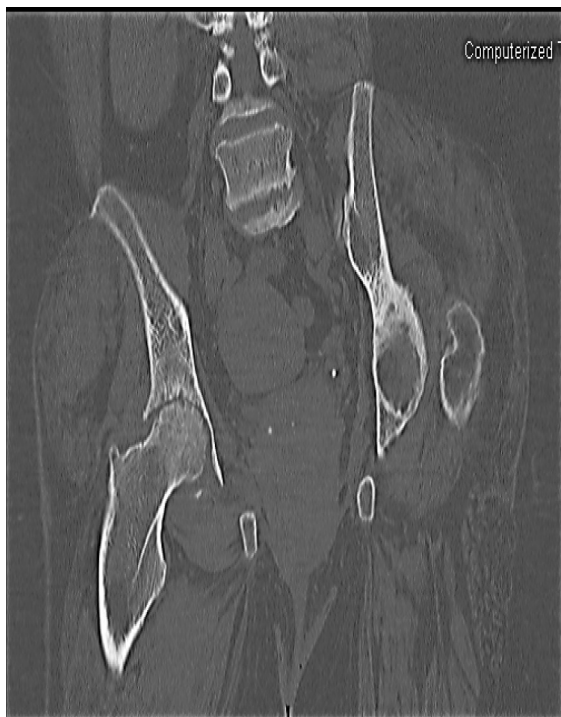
B Coronal CT scan of the pelvis without contrast: advanced degenerative changes in both hip joints with partial resorption of right femoral head
